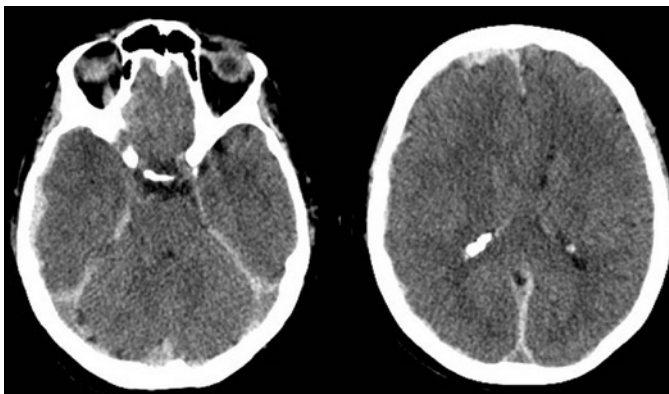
Brain CT showing SAH Fisher II
